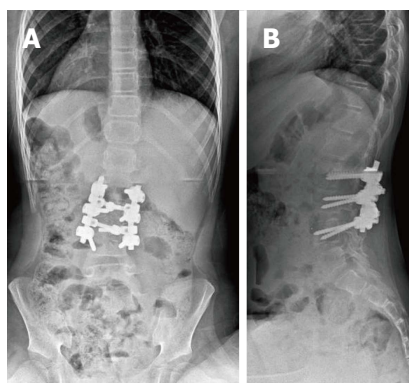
AP (A) and lateral (B) X-rays at two years follow-up showing L2-L4 vertebral fusion after posterior and anterior procedures.
